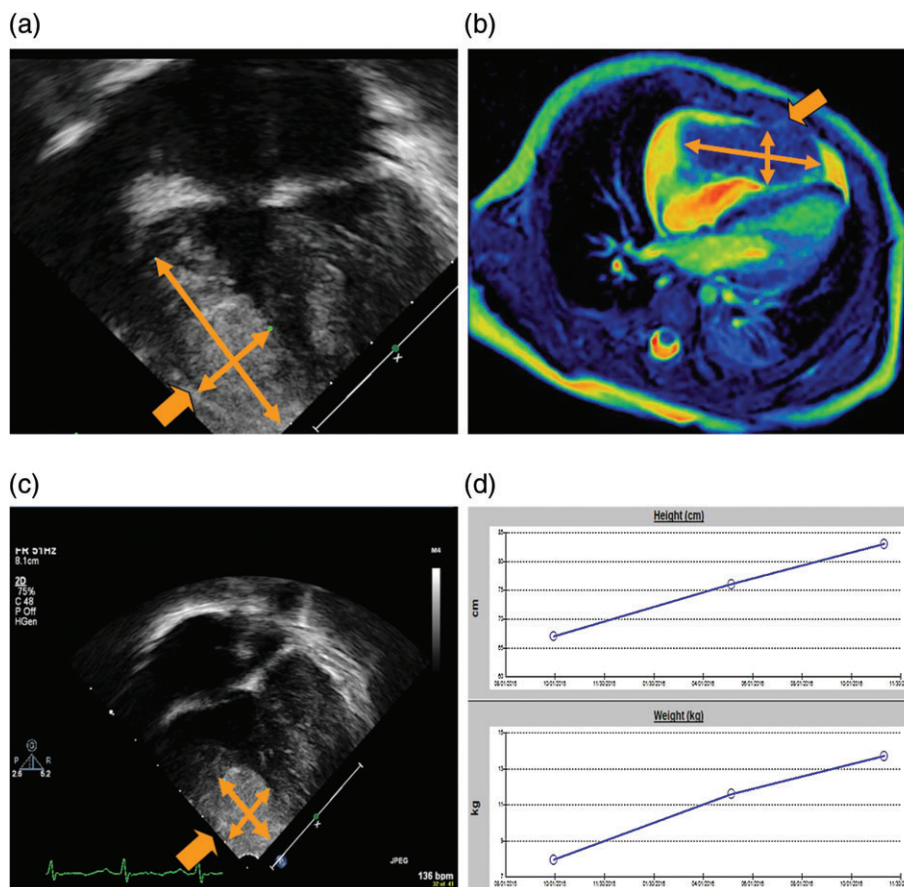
(a) Echocardiogram revealing a mass involving right ventricular free wall, measuring 3.5×1.6 cm. (b) Cardiac magnetic resonance imaging revealing a 5.4×2.6 cm mildly lobulated myocardial soft tissue mass involving the inferior free wall of the right ventricle. (c) Echocardiogram done at 18 months of age showing that the right ventricular mass has decreased to 2.5×1.4 cm. (d) Growth chart showing that he continues to grow and gain weight.
